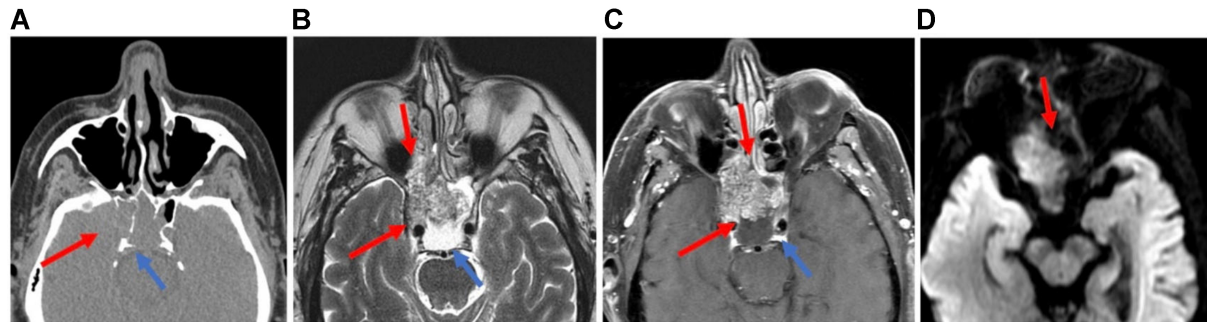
SMARCI-deficient sinonasal carcinoma: Axial CT (A) and Axial MRI (B-D: T2, post-contrast T1, DWI) images show an aggressive mass in the right sphenoid sinus with heterogeneous T2 intensity, restricted diffusion, and heterogeneous enhancement. The tumor destroys the sinus wall and the bony covering of the right internal carotid artery, directly invading the right cavernous sinus (red arrows). A T2-hyperintense, non-enhancing trapped secretion causes dehiscence of the sphenoid clivus along the posterior sinus wall (blue arrows). CT: Computed tomography; MRI: magnetic resonance imaging; DWI: diffusion-weighted imaging.
